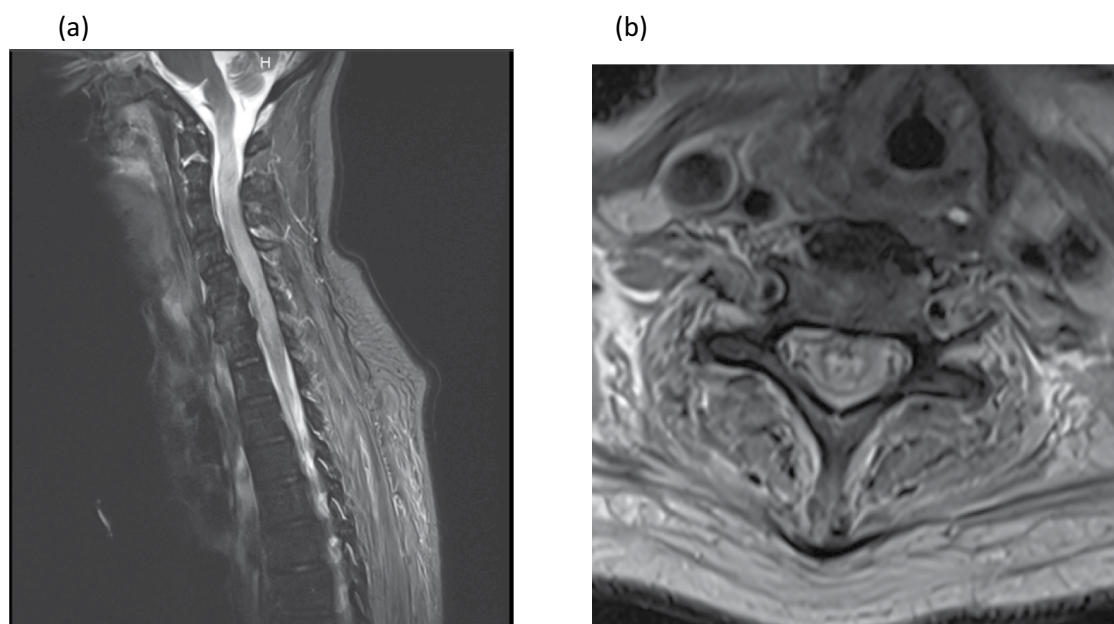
(a) Sagittal MRI of the cervical spinal cord revealing pronounced, diffuse enlargement of the spinal cord encompassing the entire cervical segment, accompanied by a diffuse hyperintense signal within the spinal cord parenchyma on T2-weighted sequences, highly
